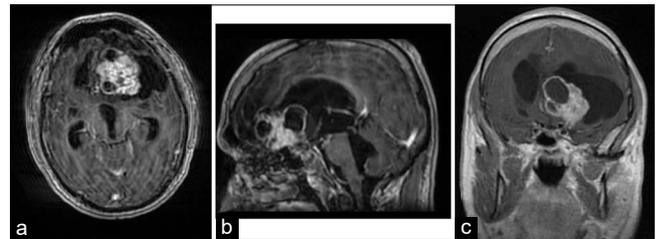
Preoperative contrast brain magnetic resonance imaging, showing the lesion with lobulated margins, non-homogeneous post contrast enhancement, solid component mixed with necrotic-colliquative areas and calcifications. (a) axial plane, (b) sagittal plane, (c) coronal plane.
